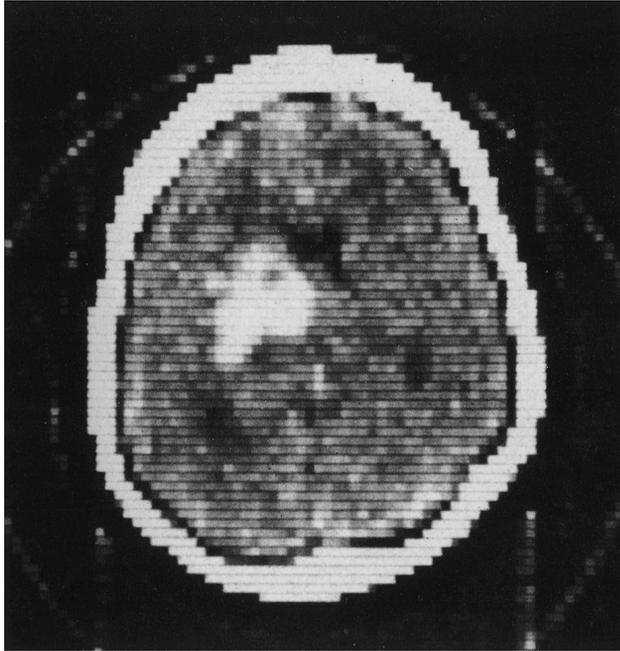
CT scan of an intracerebral haemorrhage, from the early 1970s.²²¹
